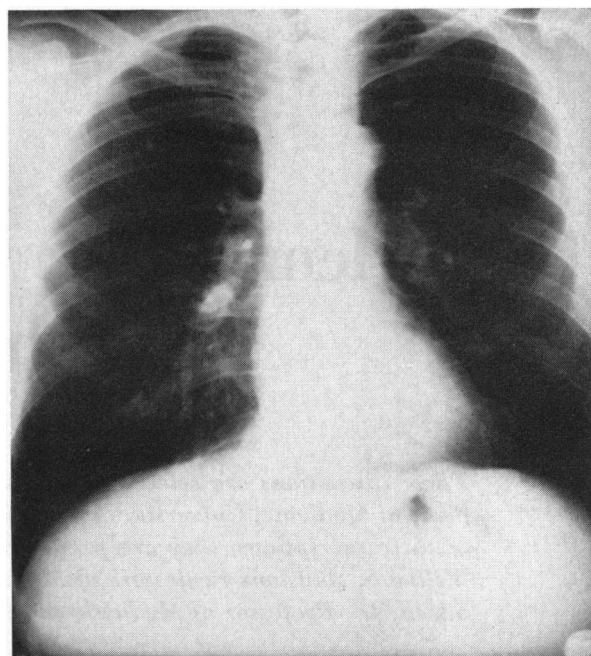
Upper, x-ray film of lungs showing granulomas in upper right field and right mid-lung field. Lower, Lateral film of chest showing granulomas.
